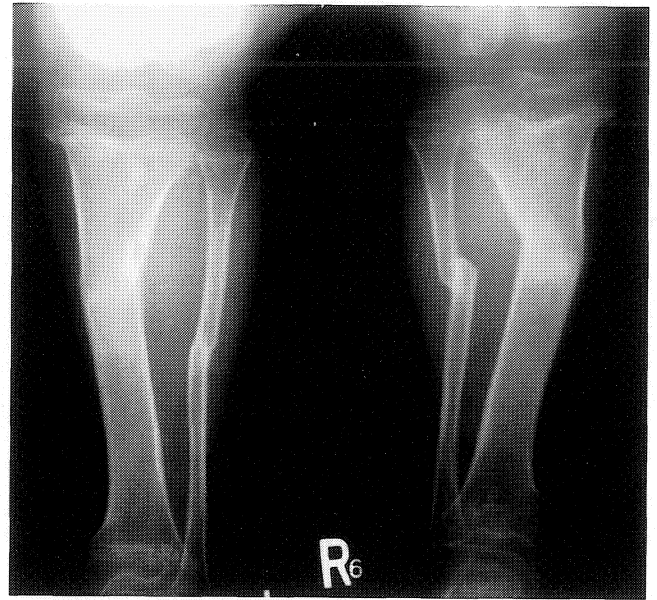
Supine radiographs after corrective osteotomy are shown to compare the joint space with the standing radiographs.
